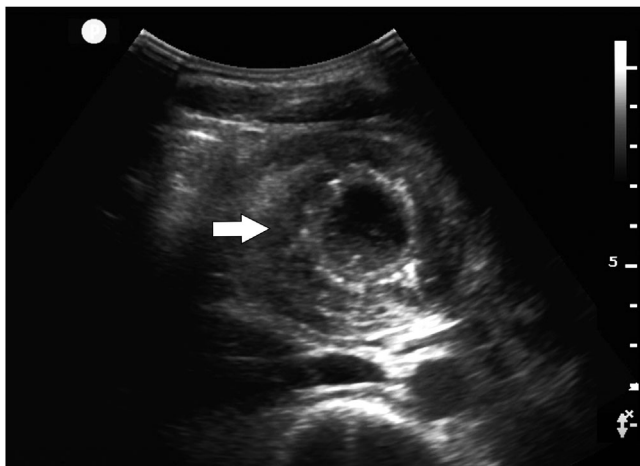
Sonographic image of the right periumbilical region in the transverse plane showed a large donut shape lesion (arrow).
